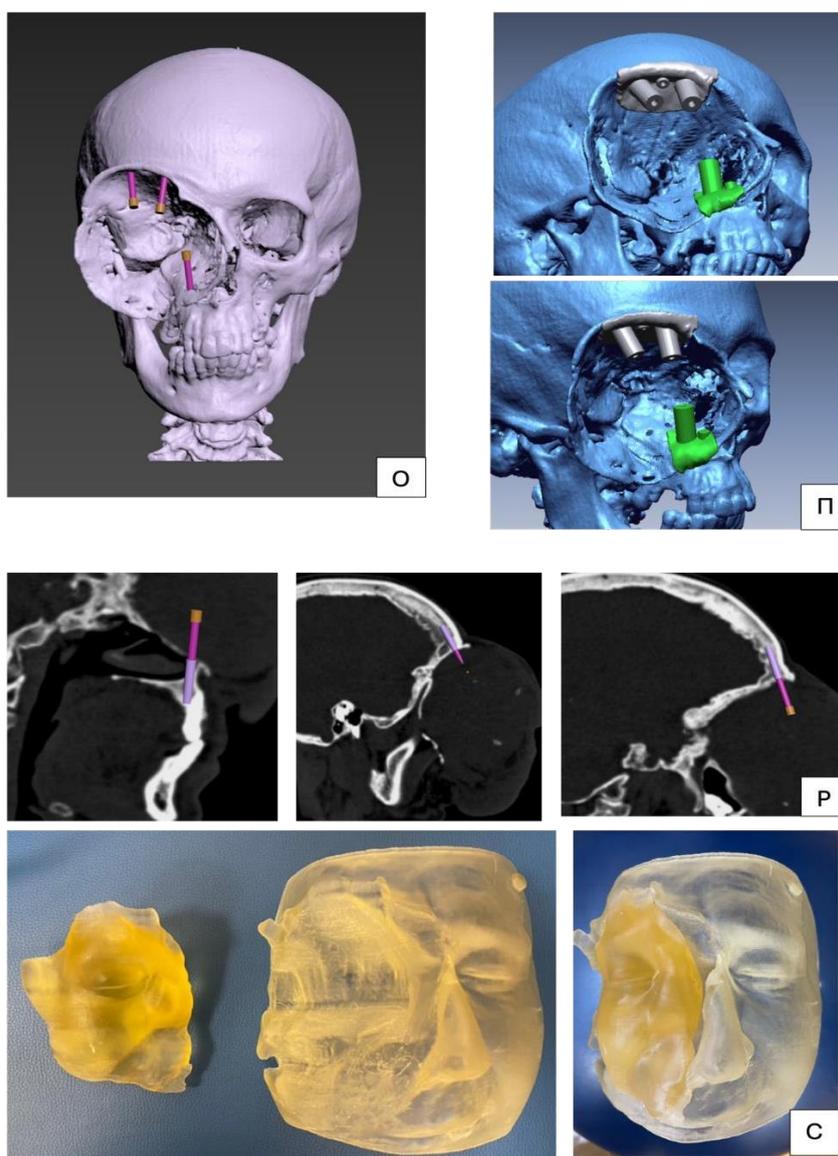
Photographs of the maxillofacial region before surgery (A–Z), MSCT (L), MRI (M), 3D modeling (O–C).
